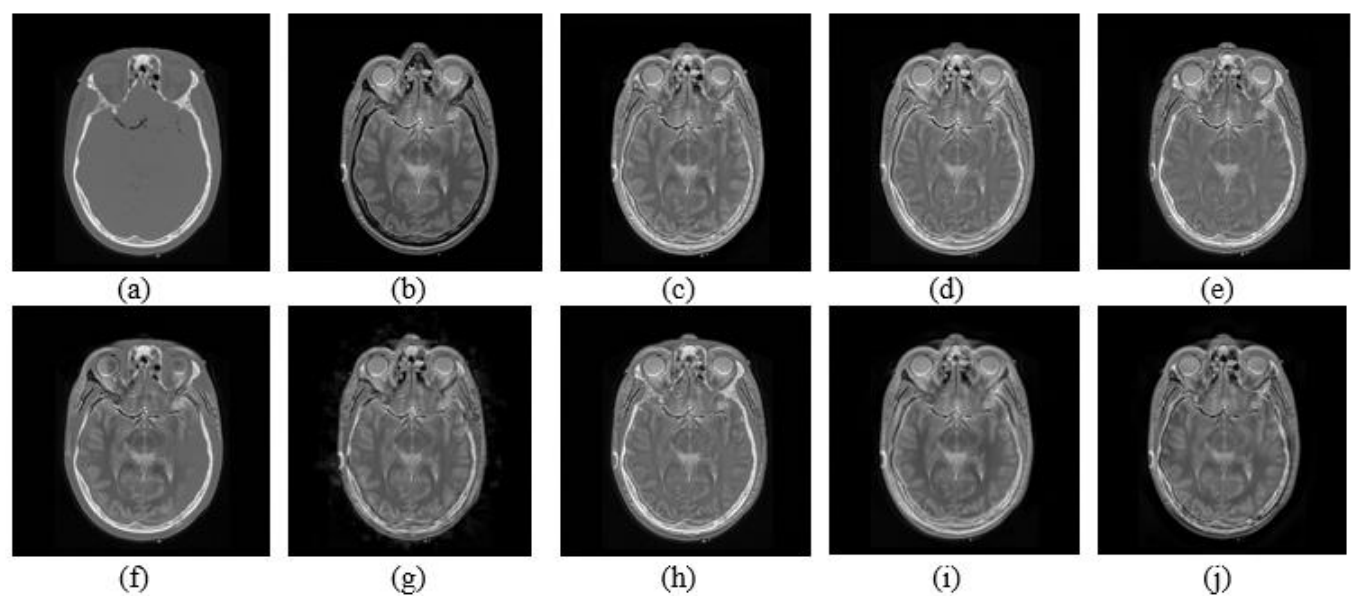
Qualitative results for MRI/CT images Date set 2 (a) CT image, (b) MRI image, (c) LEGFF, (d) FGF-XDoG, (e) MDHU, (f) FDO-DPGF, (g) CSMCA, (h) S-ADE, (i) PCLLE NSCT, (j) NSST AGPCNN.
